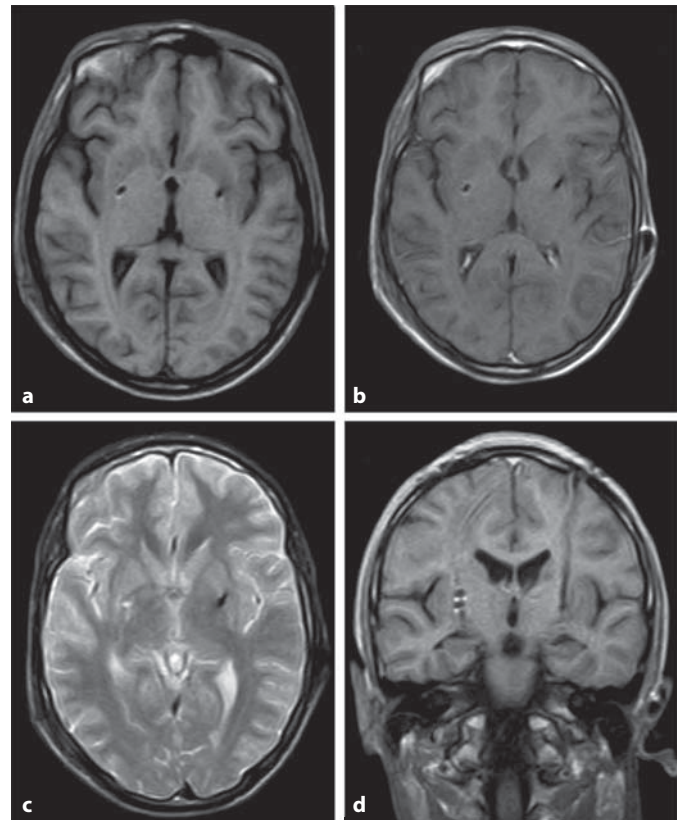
MRI performed 2 months from RF lesioning. The MR image shows a small area in the right Gpi with a T₁-weighted hyperintensity signal corresponding to the electrode contacts 1, 2 and 3 used for the RF lesions. a Axial T₁-weighted image. b Axial T₁-weighted image with gadolinium. c Axial T₂-weighted image. d Coronal T₁-weighted image with gadolinium.
